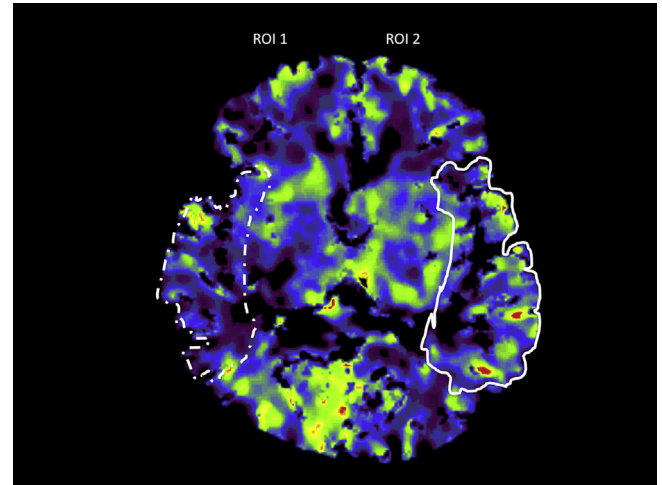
Selection of ROIs in a CBV map from FD-CTP in a patient with 75% stenosis of the right ICA. ROI1 was manually drawn to include the outer middle MCA territory, posterior MCA territory, and insula according to the ASPECT scoring system. ROI2 was manually drawn to include the corresponding territory on the nonstenotic side.
